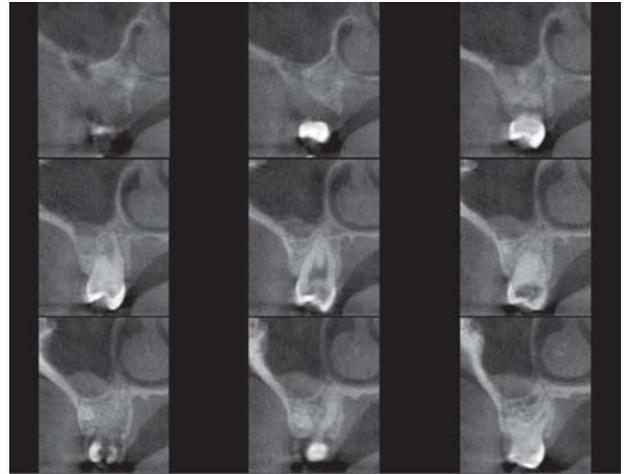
CBCT image (anterior-posterior view—right side)
